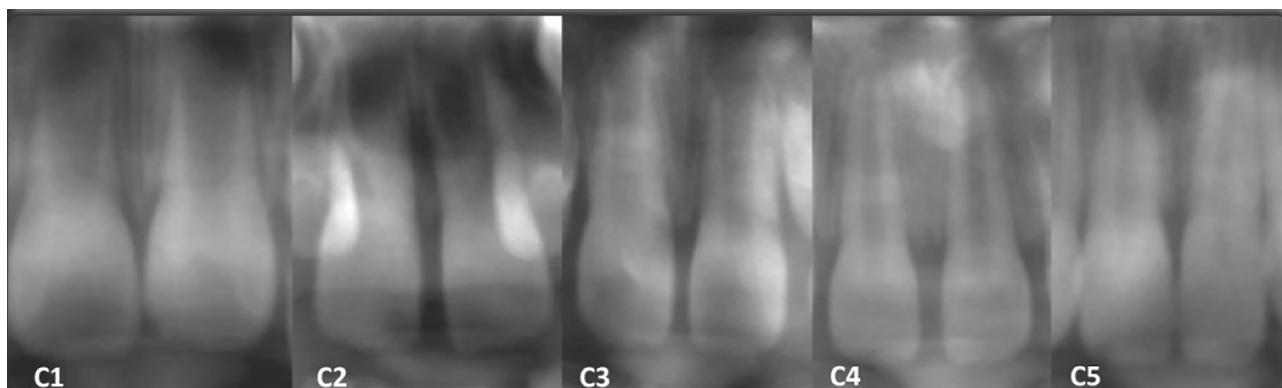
Radiographic classification of the upper permanent incisors of the patients. (C: Class).
